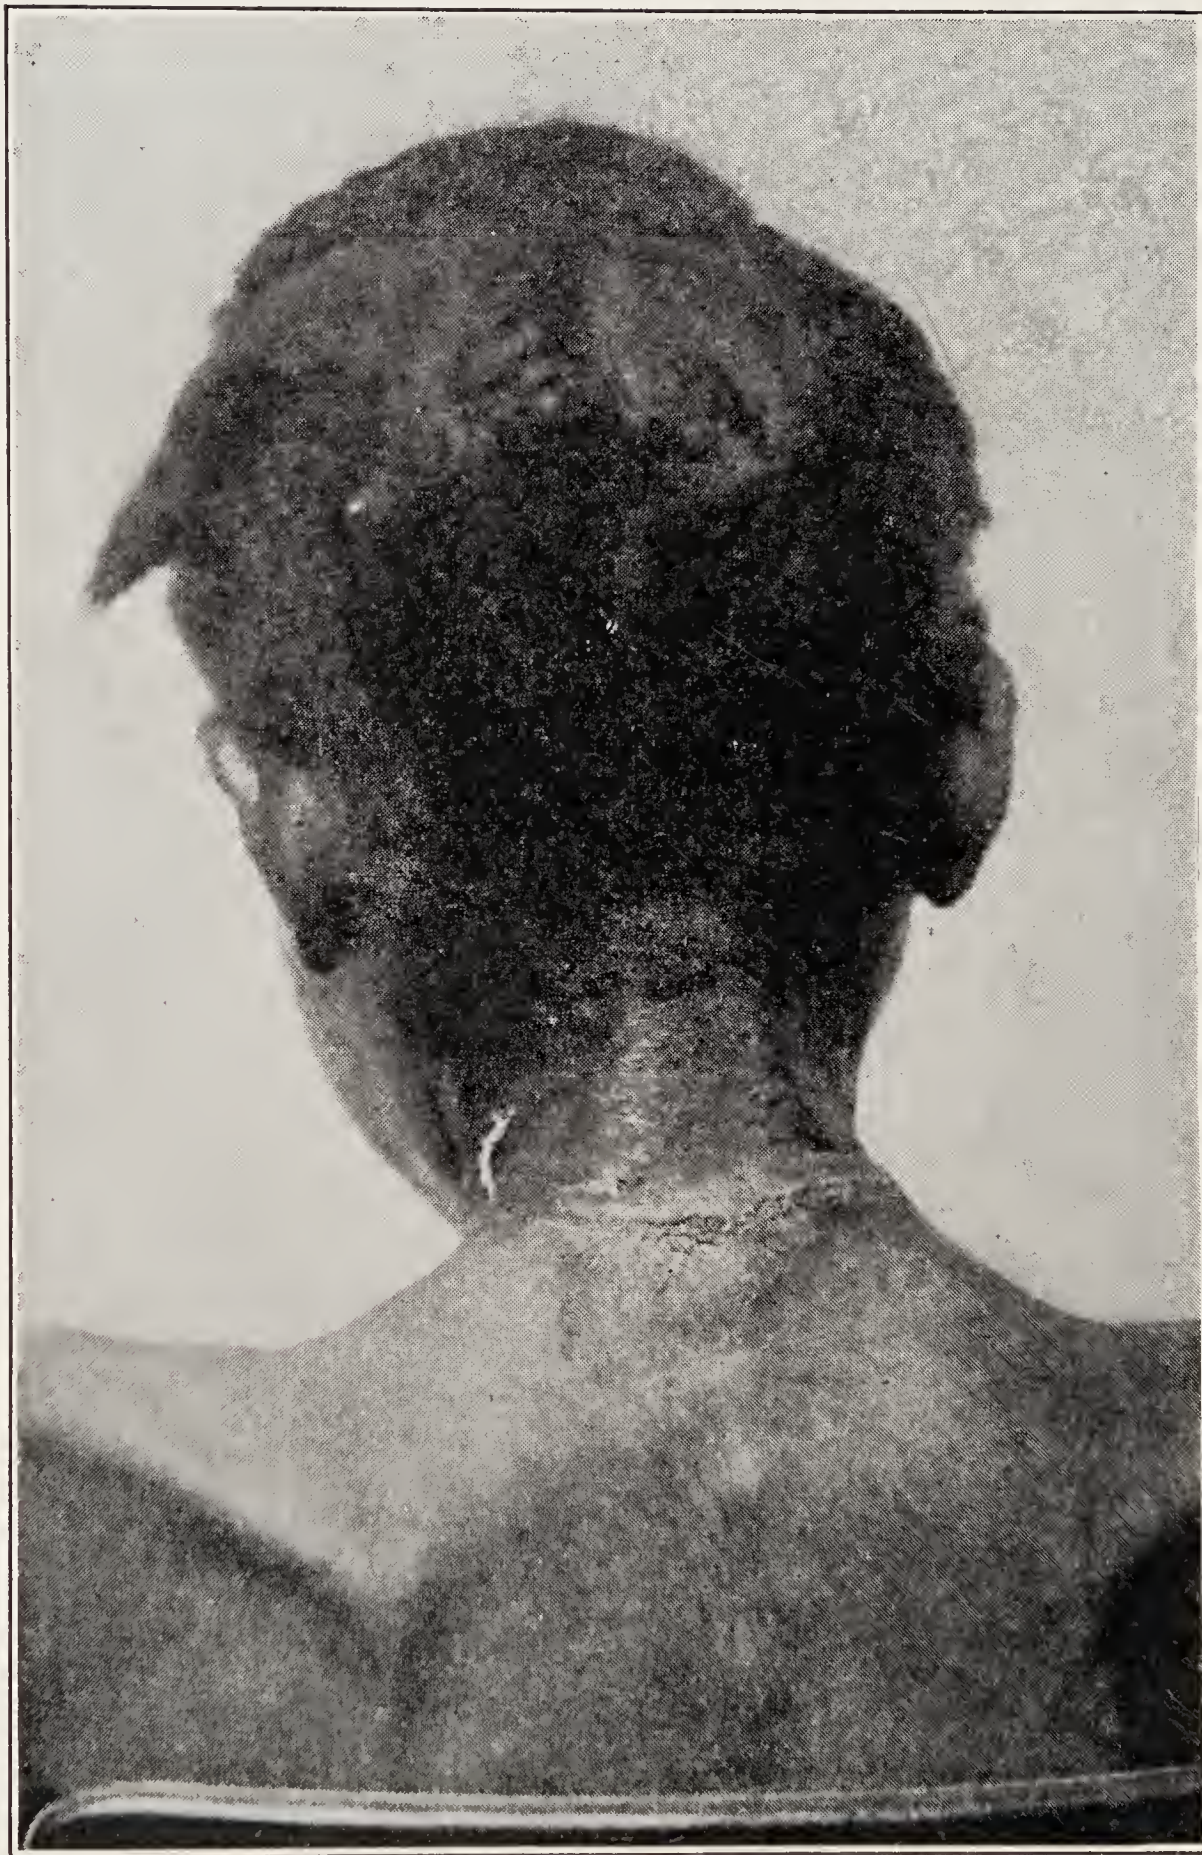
SAME PATIENT AS REPRESENTED IN FIGS. 6 AND 8, SHOWING THE POSTERIOR ASPECT OF A CASAL'S COLLAR.
